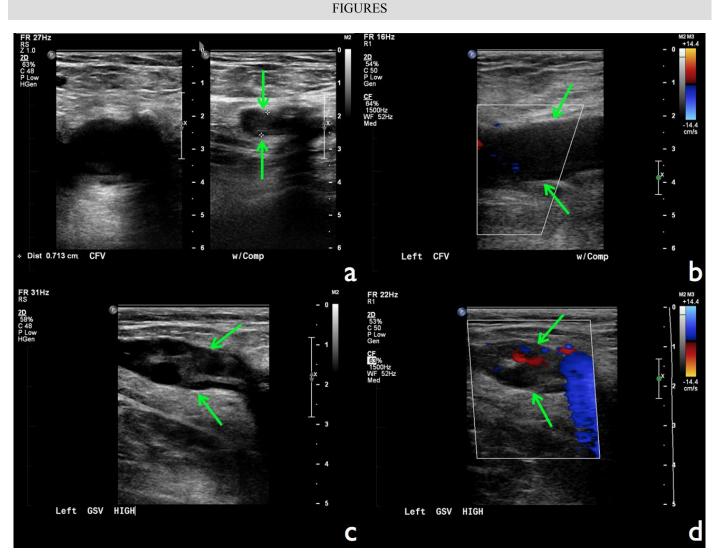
73-year-old male with extensive deep and superficial vein thrombosis. (a) 2D gray scale venous ultrasonography of the left common femoral vein before and after compression demonstrates a non-compressible echogenic material that is consistent with a clot (arrows). (b) 2D color Doppler venous ultrasonography reveals obstruction of the left common femoral vein upon compression (arrows). (c) 2D gray scale venous ultrasonography of the left greater saphenous vein demonstrates echogenic material consistent with a thrombus (arrows). (d) 2D color Doppler venous ultrasonography shows obstruction of blood flow in the left greater saphenous vein (arrows).
